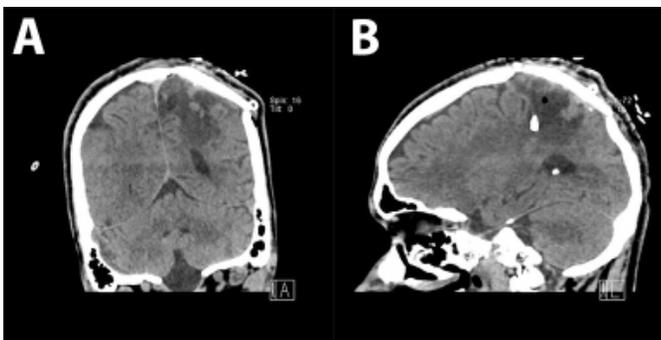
Anterior and Posterior CT Views After Surgery
